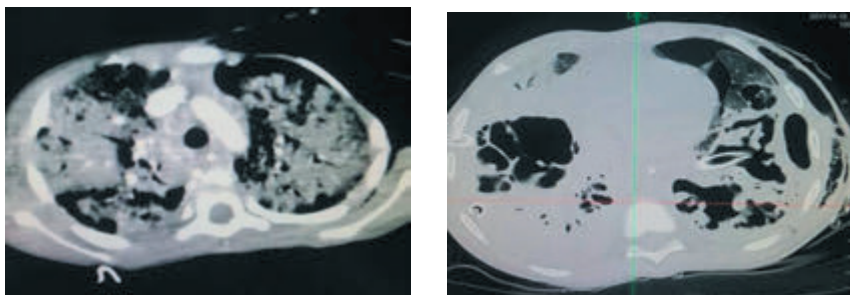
Two CT scan images of the same patient with worsening pneumonia. Images show distinct areas of low attenuation with decreased parenchymal enhancement (representing liquefaction)
